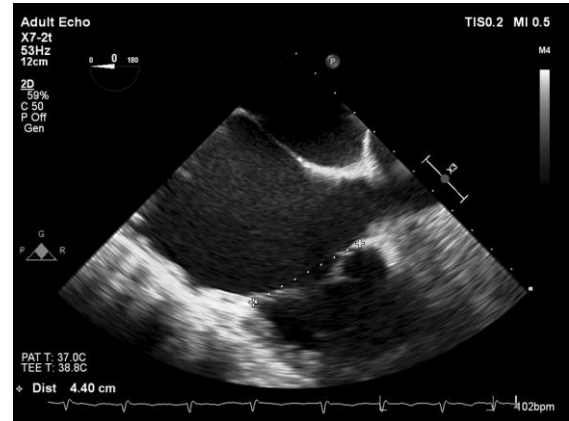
Transesophageal echocardiography revealing tricuspid ring measuring 44 mm.
